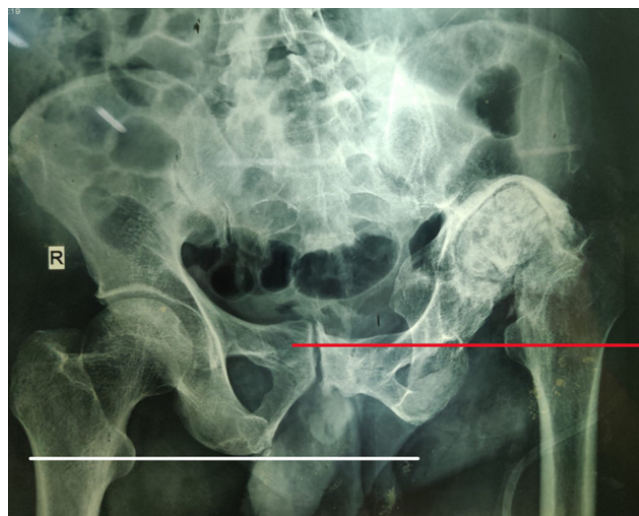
Pelvis AP x-ray taken 4 weeks post application of skeletal traction, showing gradual correction of pelvic obliquity and mild distraction at femur neck nonunion site
